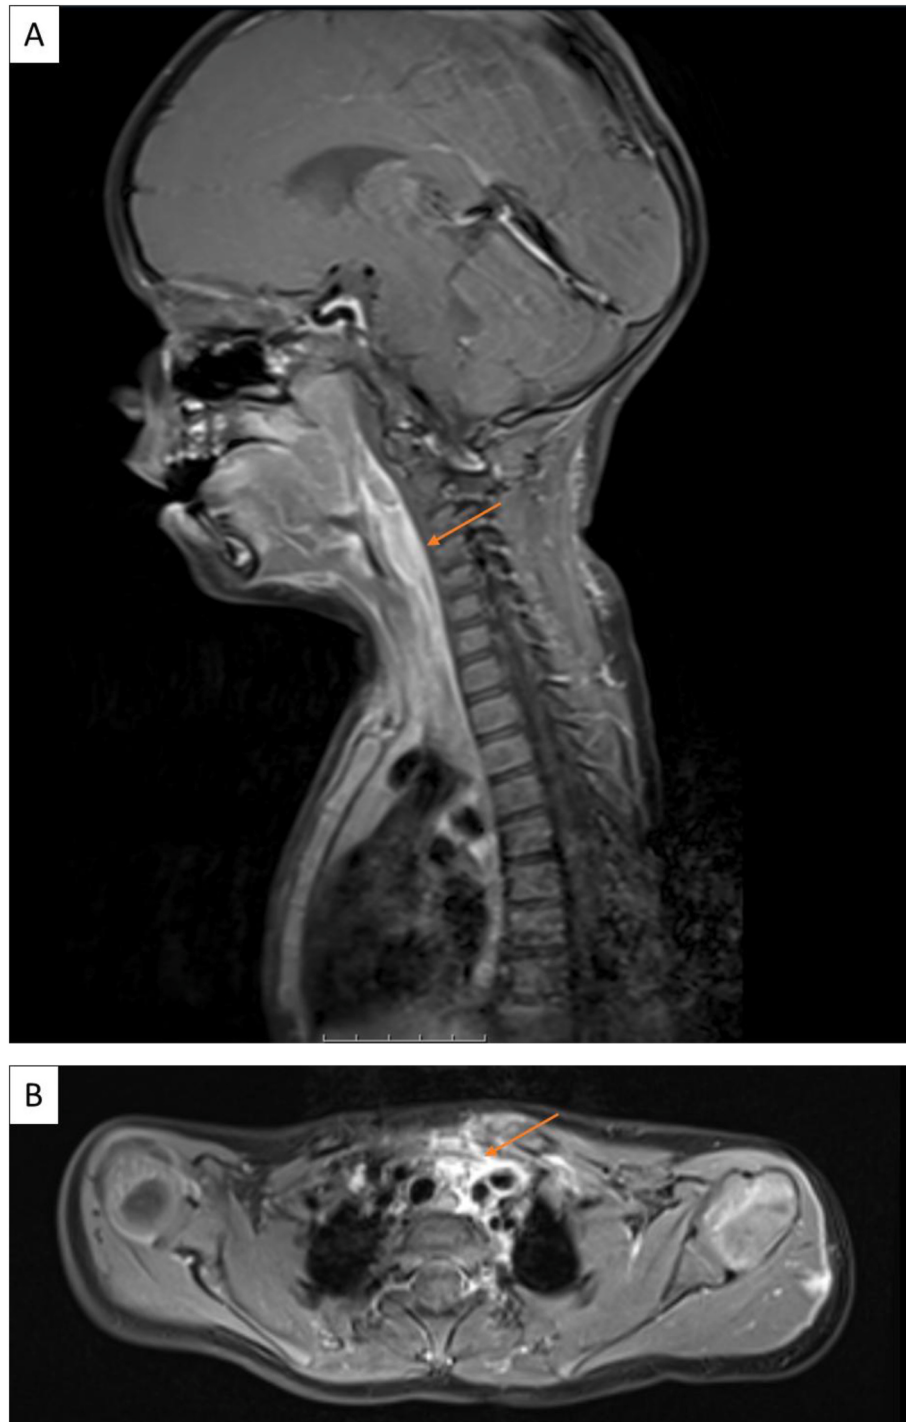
A Sagittal T1-weighted contrast-enhanced sequence MRI image showing a prevertebral abscess extending along the retropharyngeal space, with significant compression of the posterior pharyngeal wall and narrowing of the airway. B Sagittal T1-weighted contrast-enhanced sequence MRI image demonstrating caudal extension of the abscess fluid along the vascular-neural sheath into the upper mediastinum.
